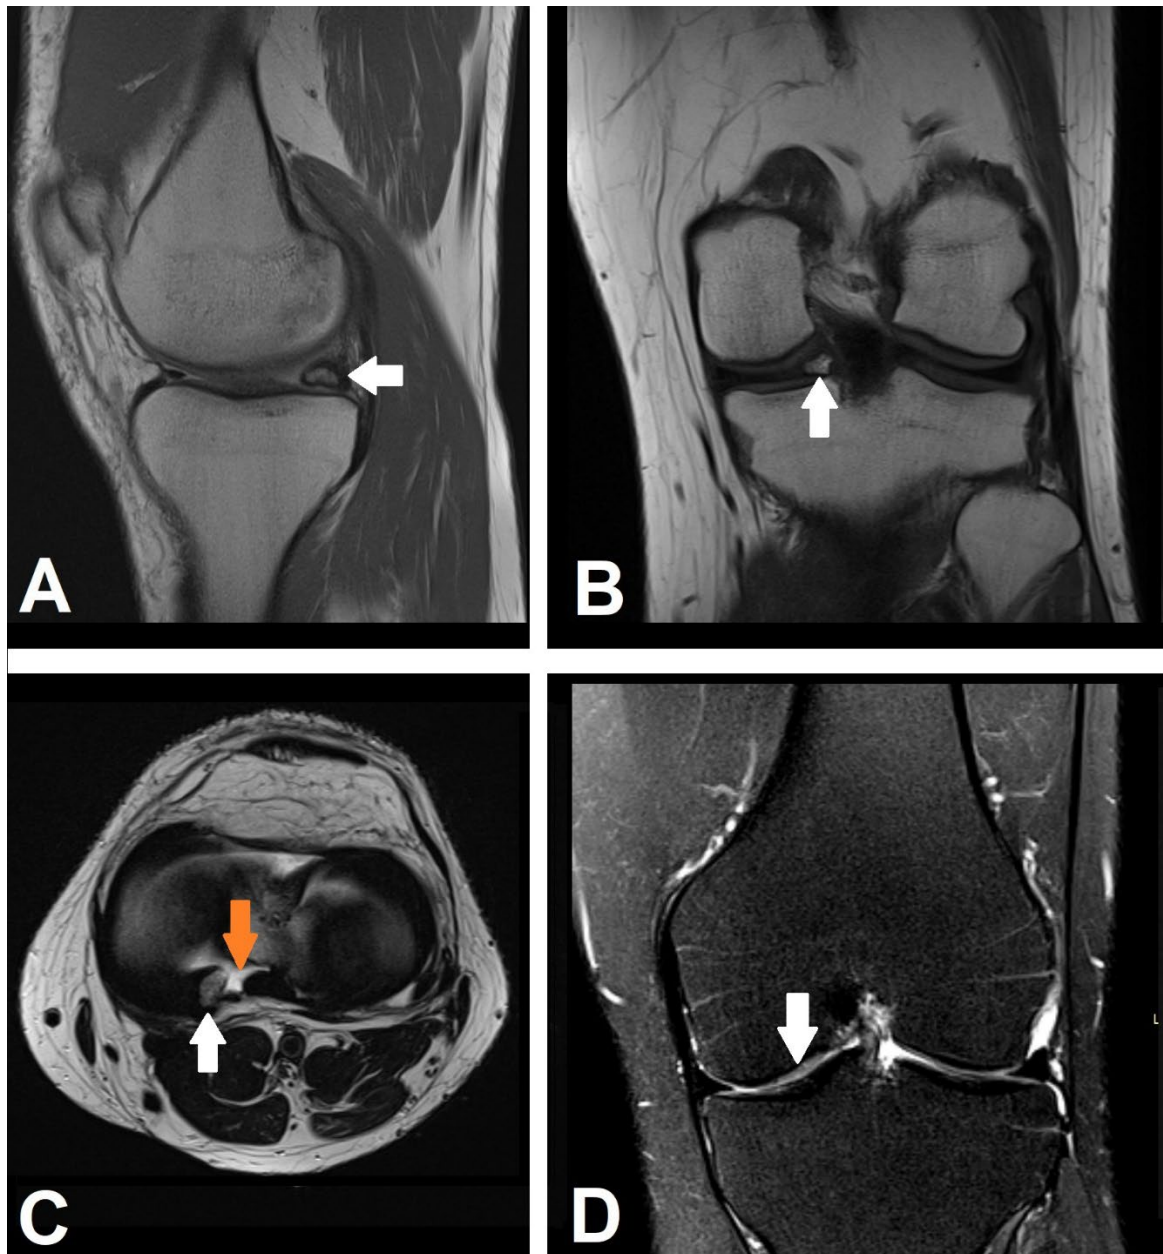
Left knee MRI in sagittal PD sequence (A), coronal T1 sequence (B) and axial T2 sequence (C) demonstrating meniscal ossicle (white arrows) and rupture of the root of the posterior horn of the medial meniscus (orange arrow in C). Left knee MRI In coronal PD FAT SAT sequence (D) detecting chondral irregularity in the weight-bearing zone of the medial femoral condyle (white arrow).
